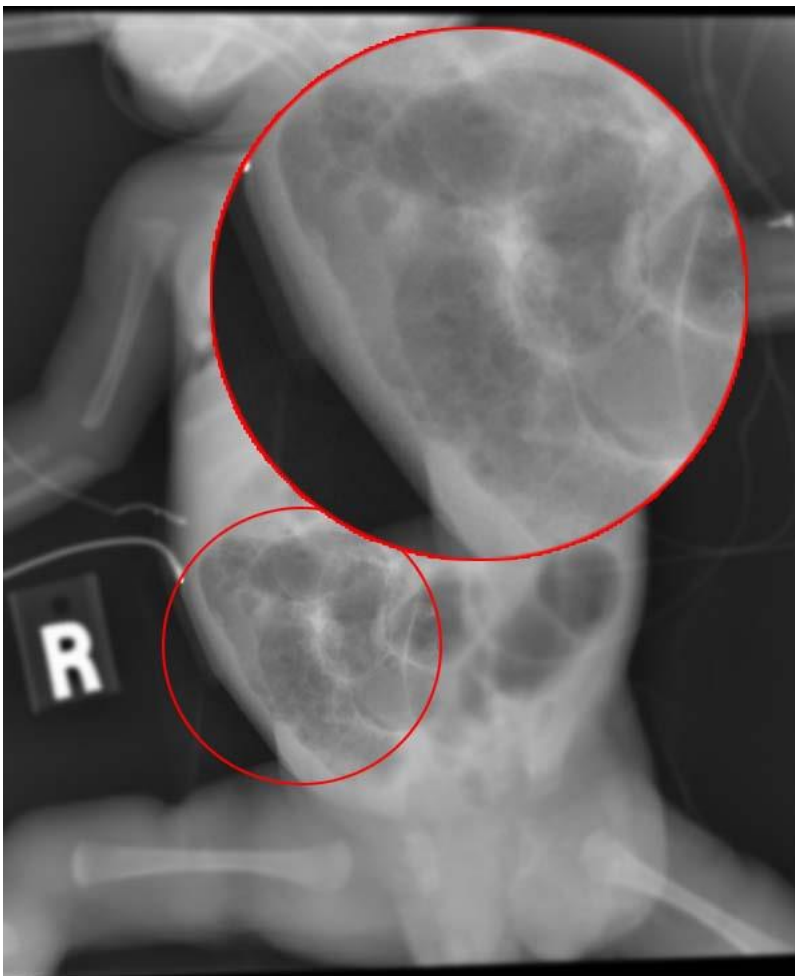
Radiograph of a baby with necrotizing enterocolitis
